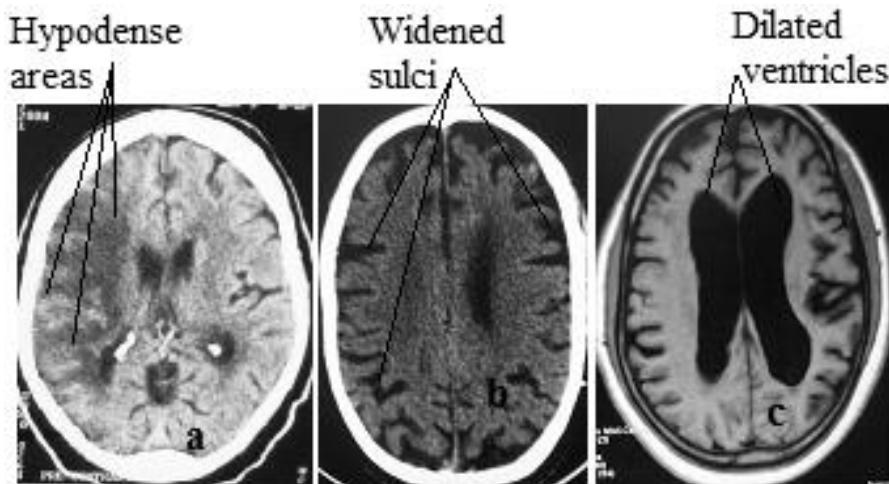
Cerebral infarct. a. Non-contrast CT scan of a patient with chronic right hemispheric cerebral infarct due to ischaemic stroke. b. Multiple infarct brain atrophy showing multiple widened sulci. c. T1-weighted MRI of a patient presenting with dementia showing more extensive multiple infarct brain atrophy evidenced by widened sulci and dilated ventricles.
